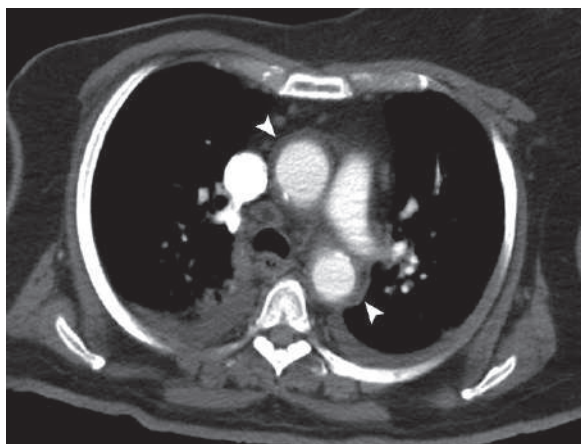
Axial CT-angiography in a 50-year-old female patient presented with nonspecific systemic inflammatory symptoms with absent right arm pulsation and limb claudication. Patient was suspected to have Takayasu arteritis by the attending physician. CTA confirmed the acute thickening of the aortic wall (*arrowheads*), with occlusion of the right subclavian artery and multiple aneurysms affecting the carotid arteries (not shown)
